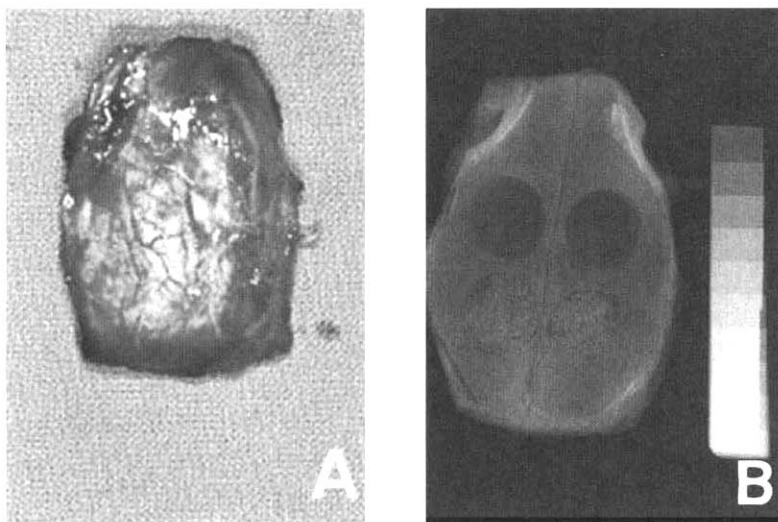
Gross and radiographic examination of surgical site
